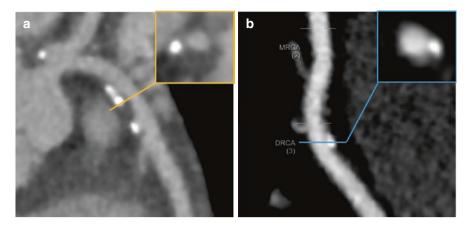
CT coronary angiogram showing mixed (a) and calcified (b) atherosclerotic plaques
